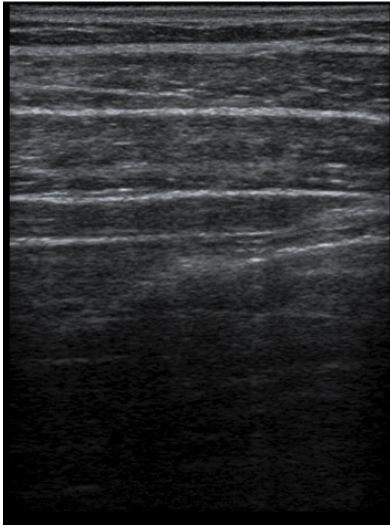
Good clarity ultrasound image of abdominal muscles: EO, IO & TrA
